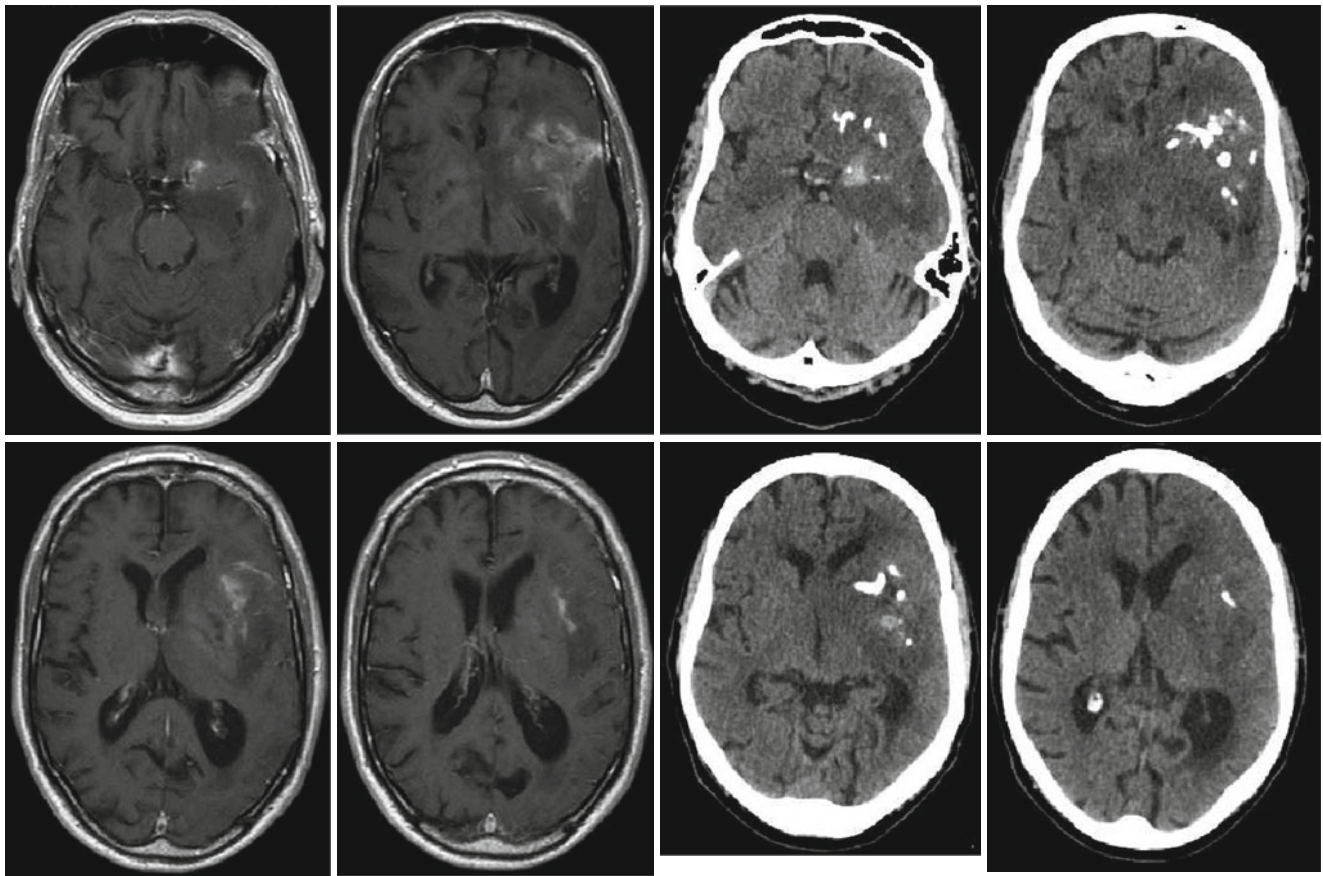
Anaplastic oligoastrocytoma with calcifications; male, 72 years. – contrast-enhanced T1 (*left*), and native CT (*right*; courtesy of the Institute of Clinical Radiology, Münster)
